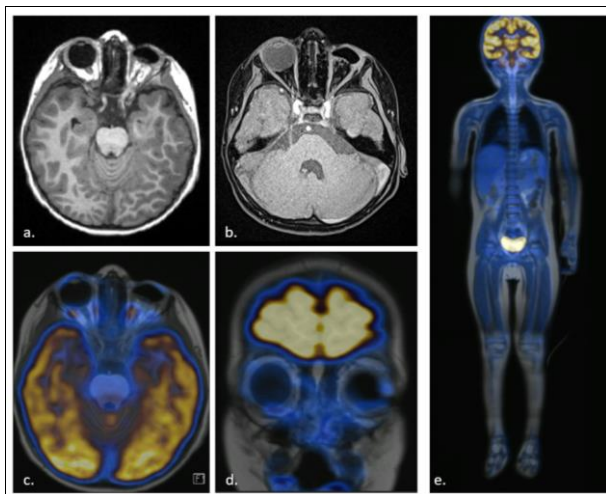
MRI and PET/MRI with 2-[¹⁸F] FDG. Postoperative changes of left ocular enucleation. a. T1WI axial image shows fibrosclerotic changes in the intraconal fat, without alterations in the extraocular muscles. b. T1WI FS axial image with contrast with no evidence of abnormal enhancement after administration of intravenous contrast medium. c. axial, d. coronal, and e. coronal whole body PET/MRI without areas of abnormal focal increase in metabolism in the orbital fossa nor in the whole body
